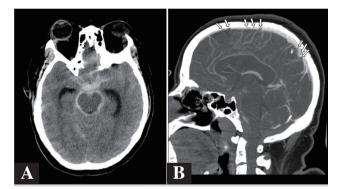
(A)CT head plain showing extensive subarachnoid hemorrhage; (B) CT venogram showing multiple small eccentric thrombi (arrows) in the superior sagittal sinus
